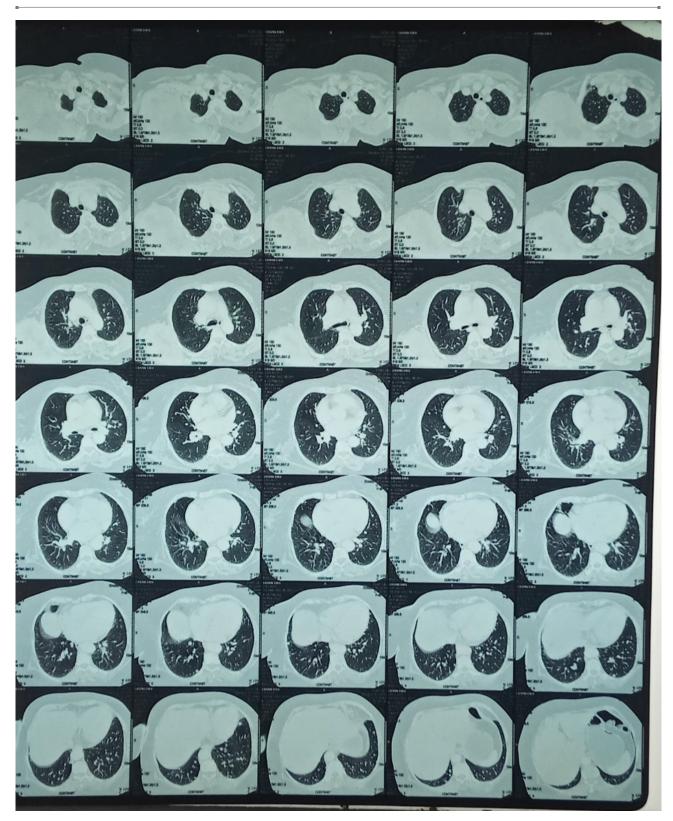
CT lung window showing small nodules representing metastasis.
